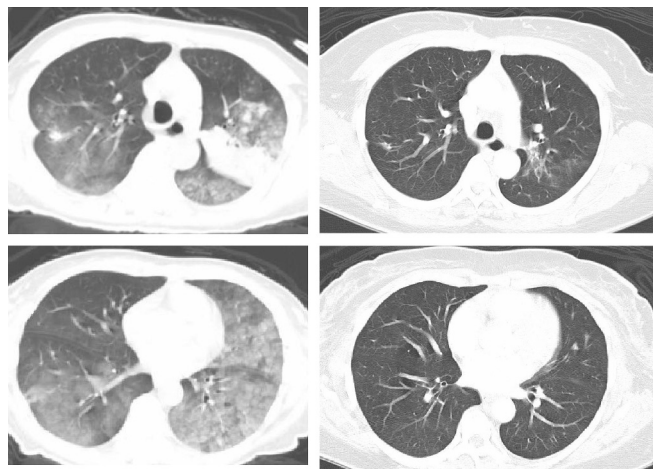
Near complete response to therapy with erlotinib. Computed tomography (CT) chest at initiation of treatment with erlotinib (left) and after 6 months of therapy with erlotinib (right).
